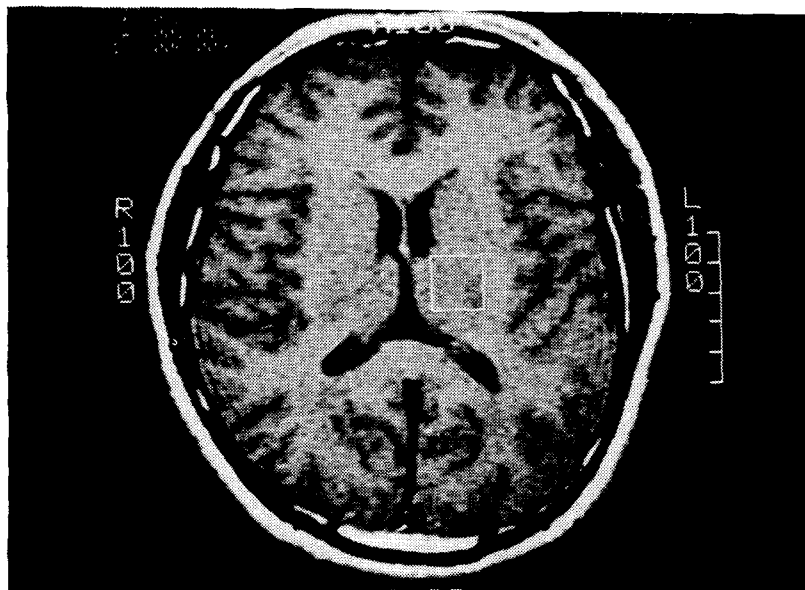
T1-weighted axial brain MR image of a normal volunteer defining the VOI
